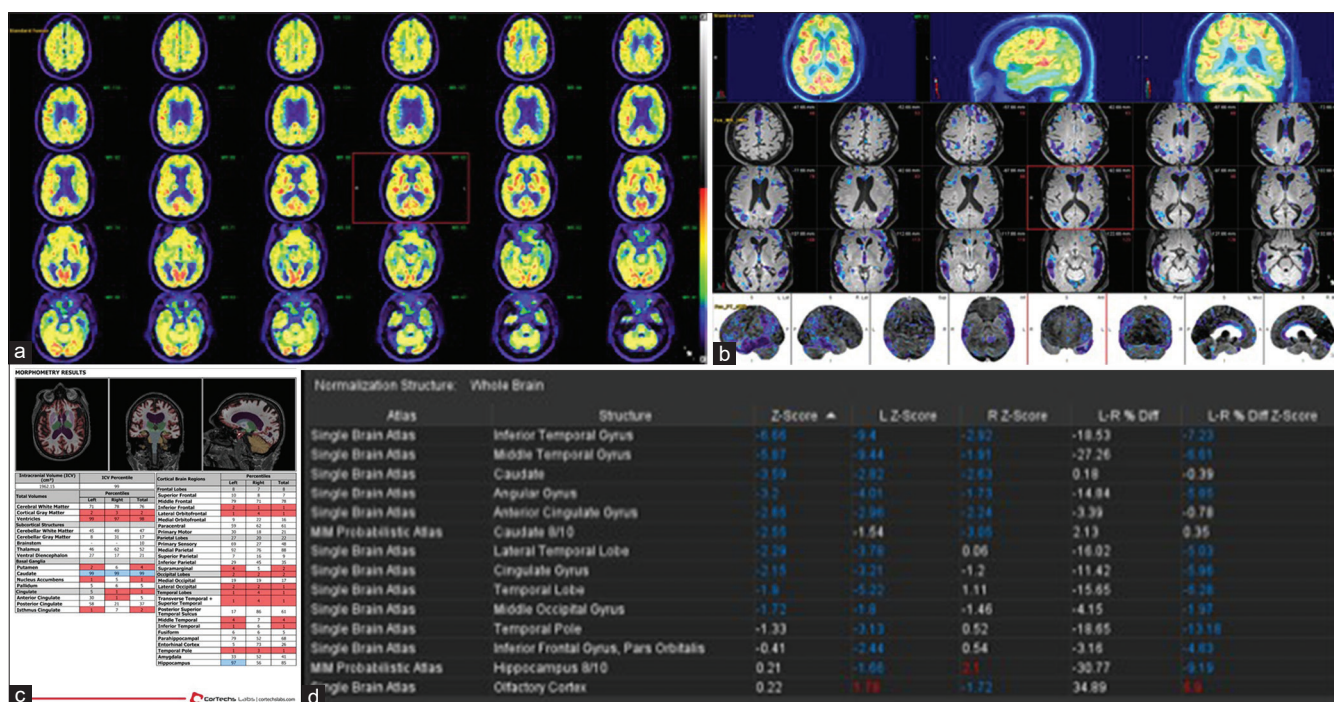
(a) 82-year-old male with semantic PPA: fusion fluorodeoxyglucose positron emission tomography and fluid-attenuated inversion recovery magnetic resonance imaging axials. (b) 82-year-old male with semantic PPA: z-score overlay on cortical surface maps. (c) 82-year-old male with semantic PPA: NeuroQuant morphometric analysis. (d) 82-year-old male with semantic PPA: MIMneuro software z-score output
